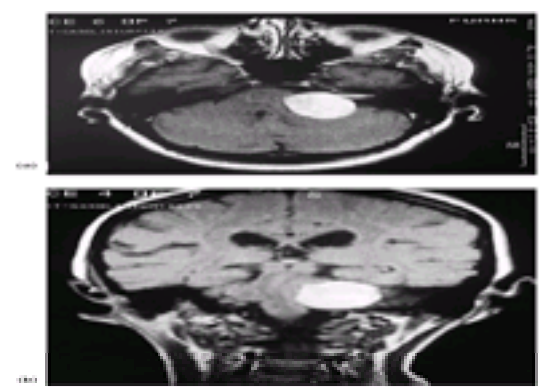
Large acoustic neuroma visible as a bright spherical lesion on the right of (a) axial MRI scan; (b) coronal MRI scan.
